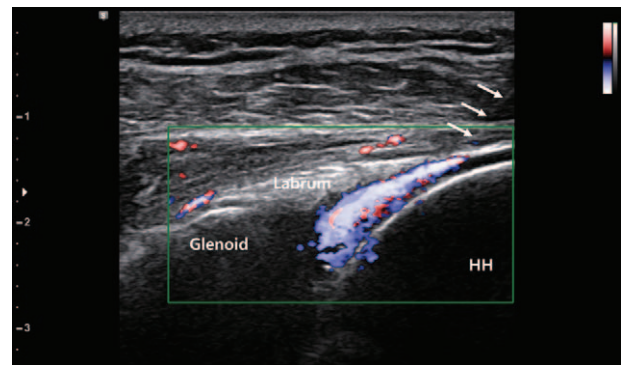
Intra-articular shoulder injection was confirmed using color Doppler. Arrow, needle. HH=humerus head.
